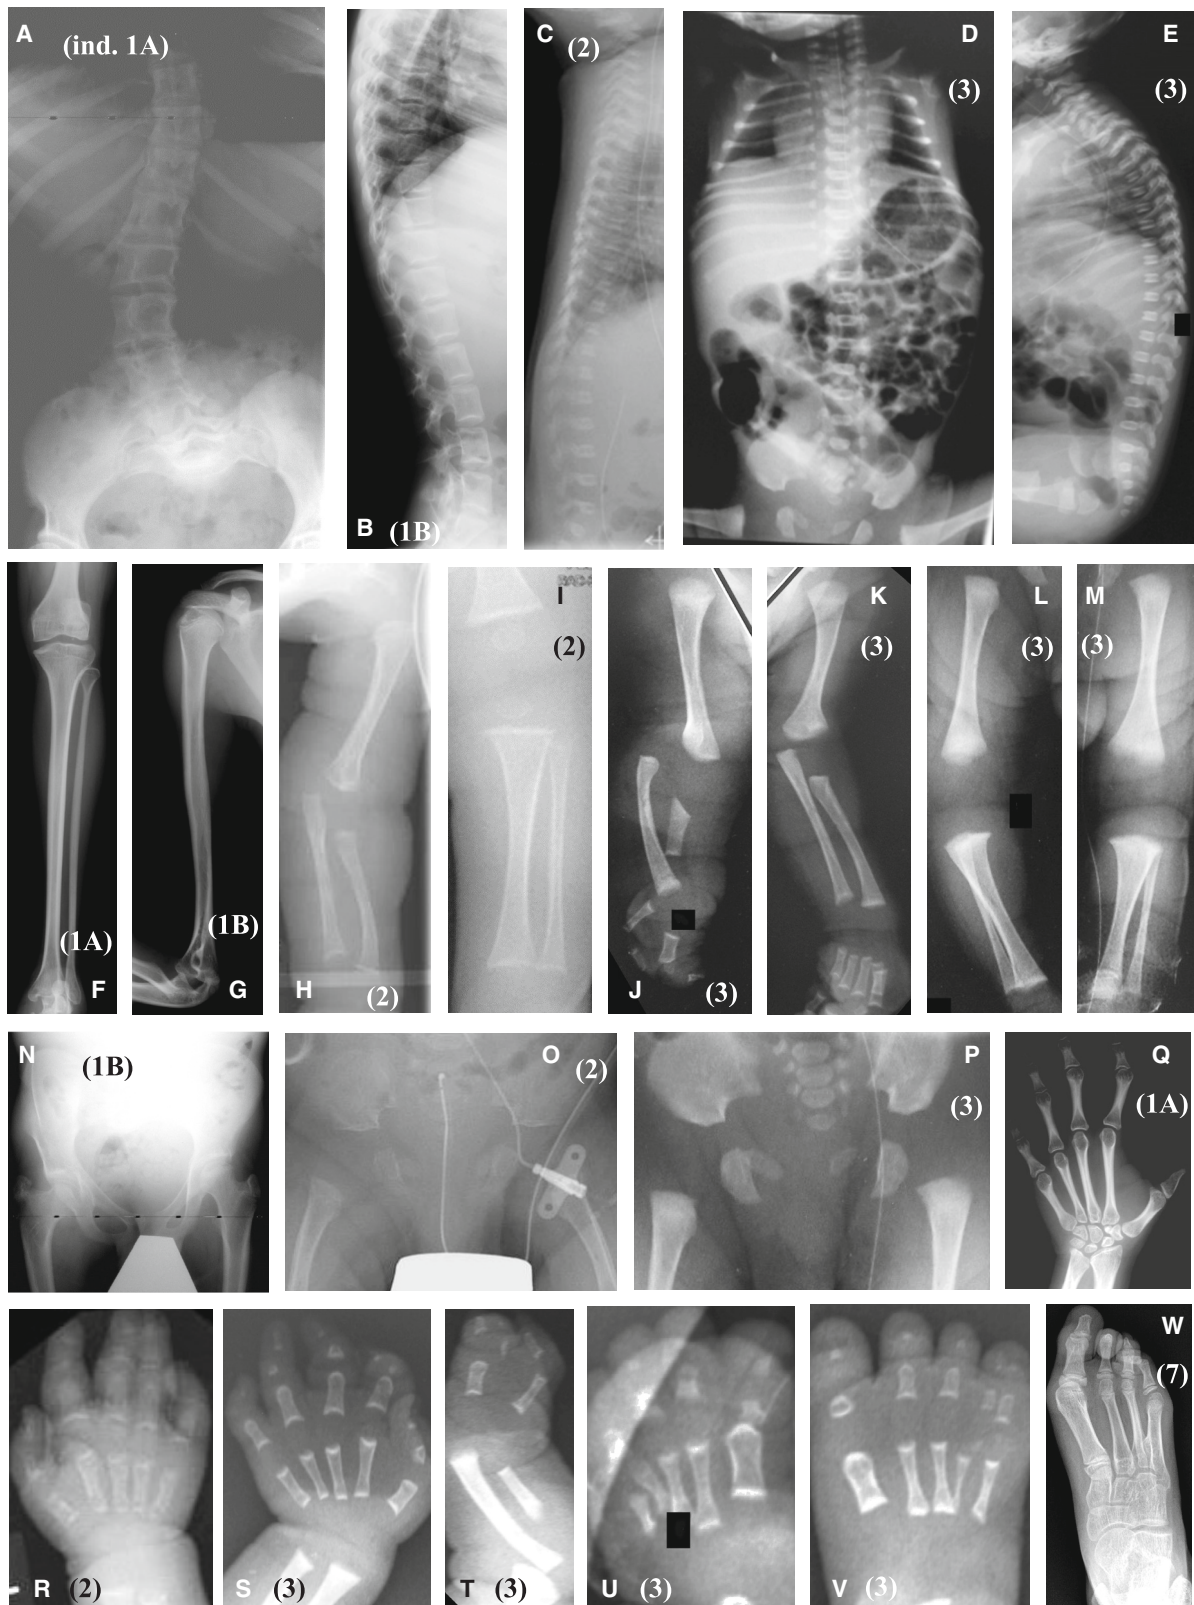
Radiographs of affected individuals
